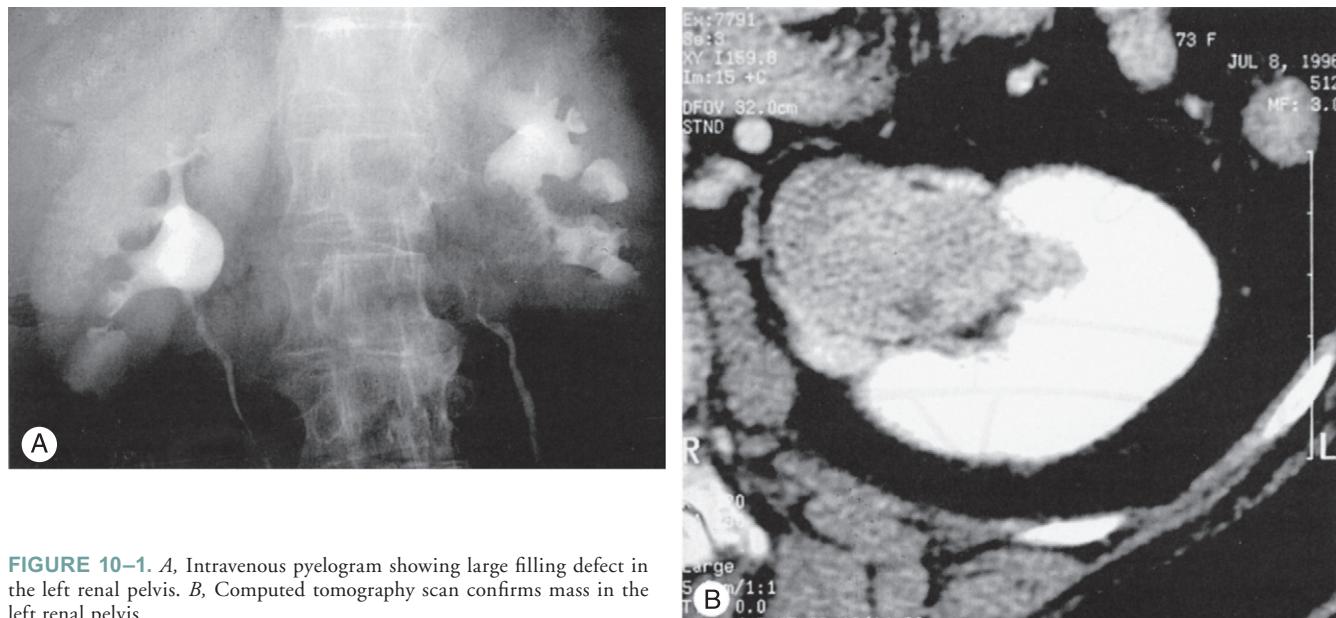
A*, Intravenous pyelogram showing large filling defect in the left renal pelvis. *B*, Computed tomography scan confirms mass in the left renal pelvis
